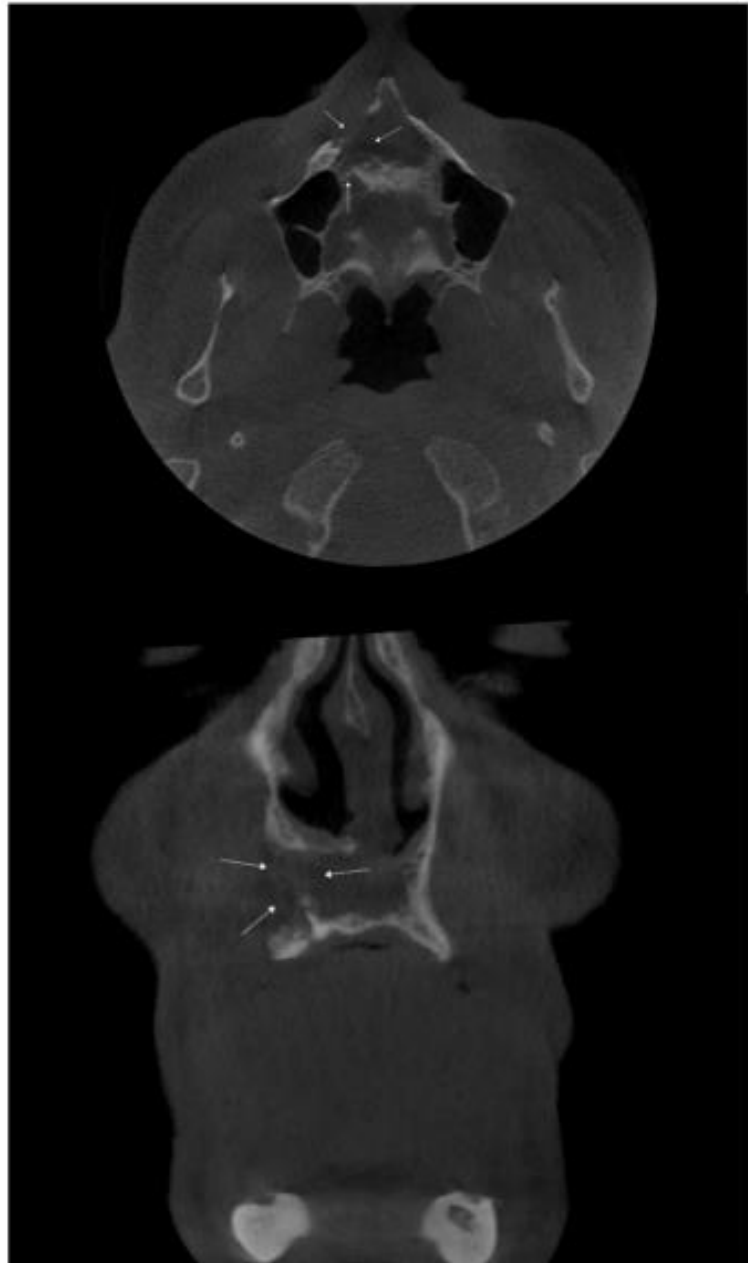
CT facial bones showing destruction of the anterior maxillary bone, as well as the central superior cortex and the hard palate. a) Coronal view. b) Axial view
